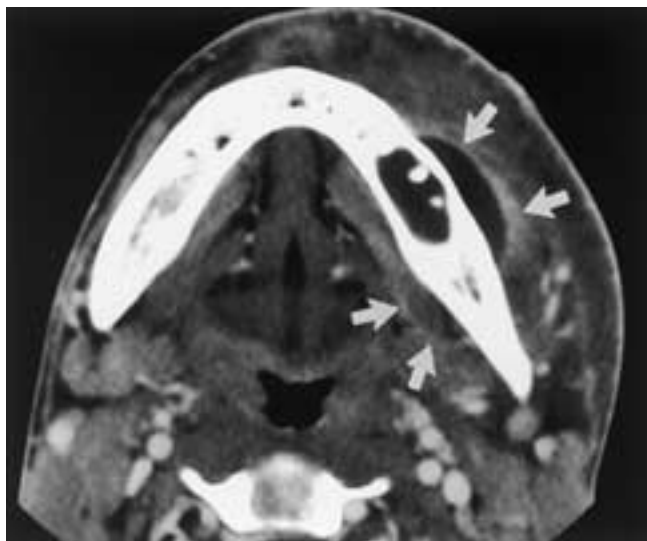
Periapical abscess in a 16-year-old male with tooth pain and left facial swelling. Contrast-enhanced axial CT scan shows an abscess cavity within the mandible in the region of the first molar. Rim-enhancing abscesses also involve both the buccal and lingual gingiva (arrows).
